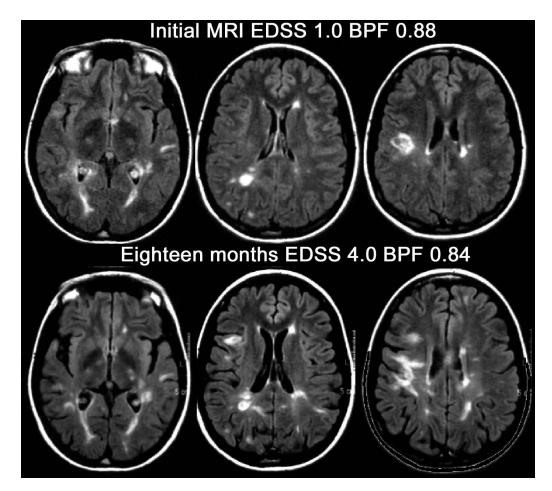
Progressive brain atrophy in MS over 18 months shown on representative MRI scans. A 22 year-old woman with relapsing-remitting MS and a disease duration of two years received MRI of the brain (top row). She had mild physical disability on the Expanded Disability Status Scale (EDSS) of 1.0. Brain parenchymal fraction (BPF), performed at the Buffalo Neuroimaging Analysis Center, was 0.88, which is normal for age. The patient experienced frequent relapses and disease progression during the next several months. Physical disability increased to a moderate level with an EDSS score of 4.0. A follow-up MRI was performed (remote from corticosteroid use) 18 months after the initial MRI. Note the marked enlargement of the cortical sulci, sylvian fissures, and third and lateral ventricles. BPF decreased by 4.5% to 0.84, which is ~5 standard deviations below normal.
